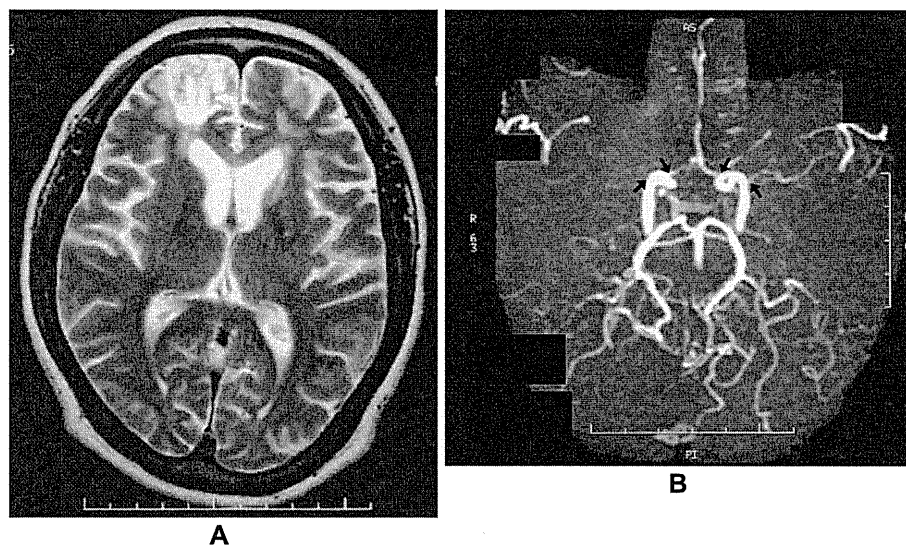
Brain magnetic resonance imaging (MRI), which had been performed when Patient 1 was transferred to the emergency room for convulsions at 40 years of age, showed an old infarction in the right frontal lobe (left panel), while brain magnetic resonance angiography (MRA) showed severe narrowing in the end of both sides of the internal carotid artery (right panel). The narrowing in the proximal region of both sides of the anterior cerebral and middle cerebral arteries is indicated by arrows.
